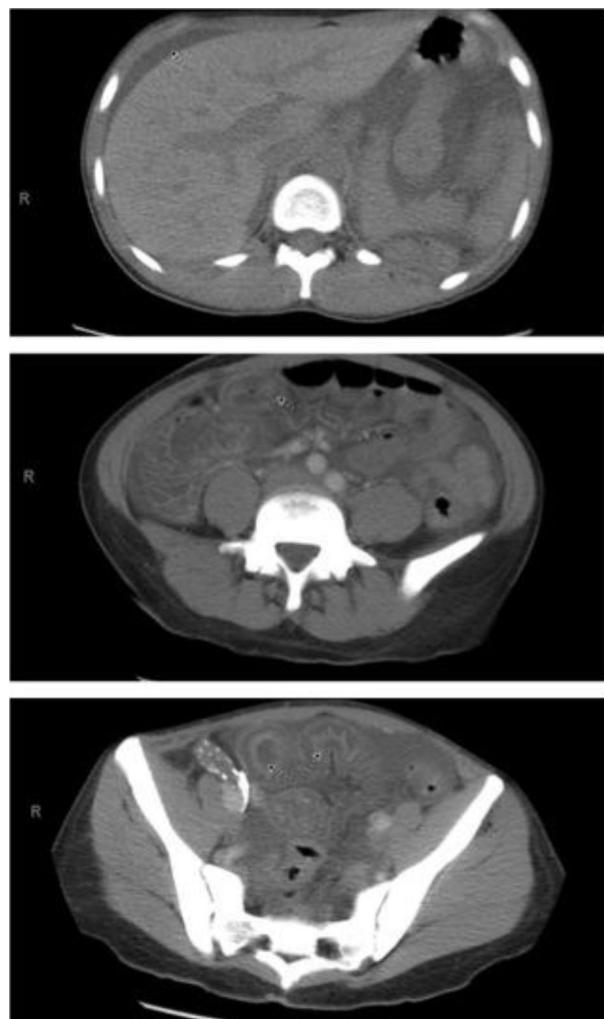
Contrast CT findings of visceral angioedema. (a) Peri-hepatic fluid accumulation. (b, c) Small bowel wall edema, Target sign.
